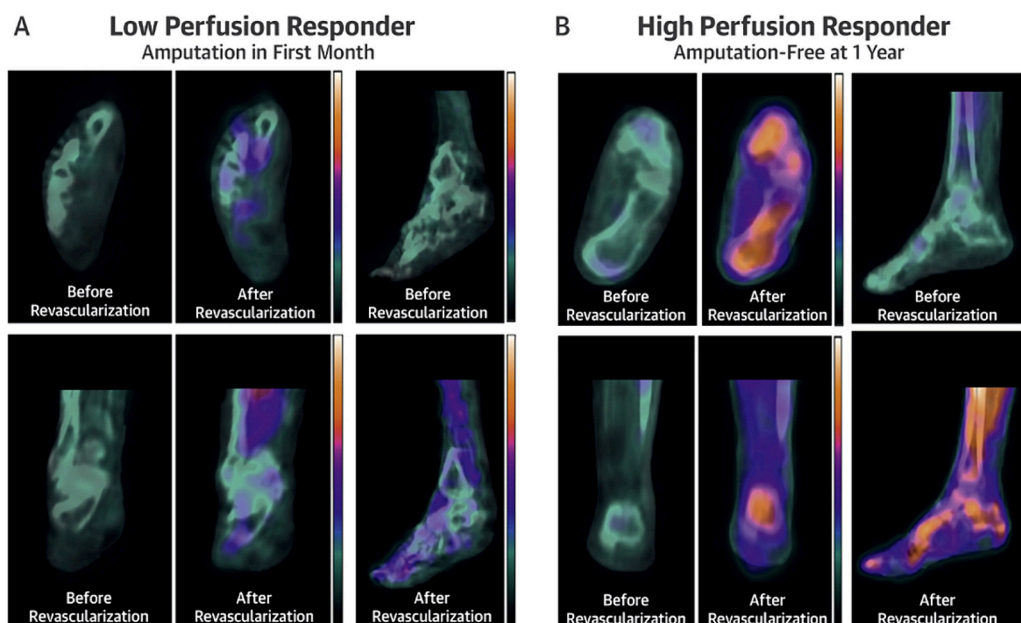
A Combined SPECT and CT Protocol Evaluated by Chout et al., Has Shown Promising Results as a Potential Modality to Assess Post-Revascularization Outcomes in Patients with Critical Limb-threatening Ischemia (CLTI) and Diabetes. According to the Protocol, a Low-Perfusion Responder (Fig. A) Was Found to Have Lower Amputation-Free Survival at 3 and 12 Months Compared to the High-Perfusion Responder (Fig. B) After Endovascular Revascularization. The Sensitivity and Specificity of the Imaging Were Reported as 78.6 % and 81.8 %, Respectively. *Figure From: Chou, T.H. et al. J Am Coll Cardiol Img. 2021;14(8):1614–24.*
